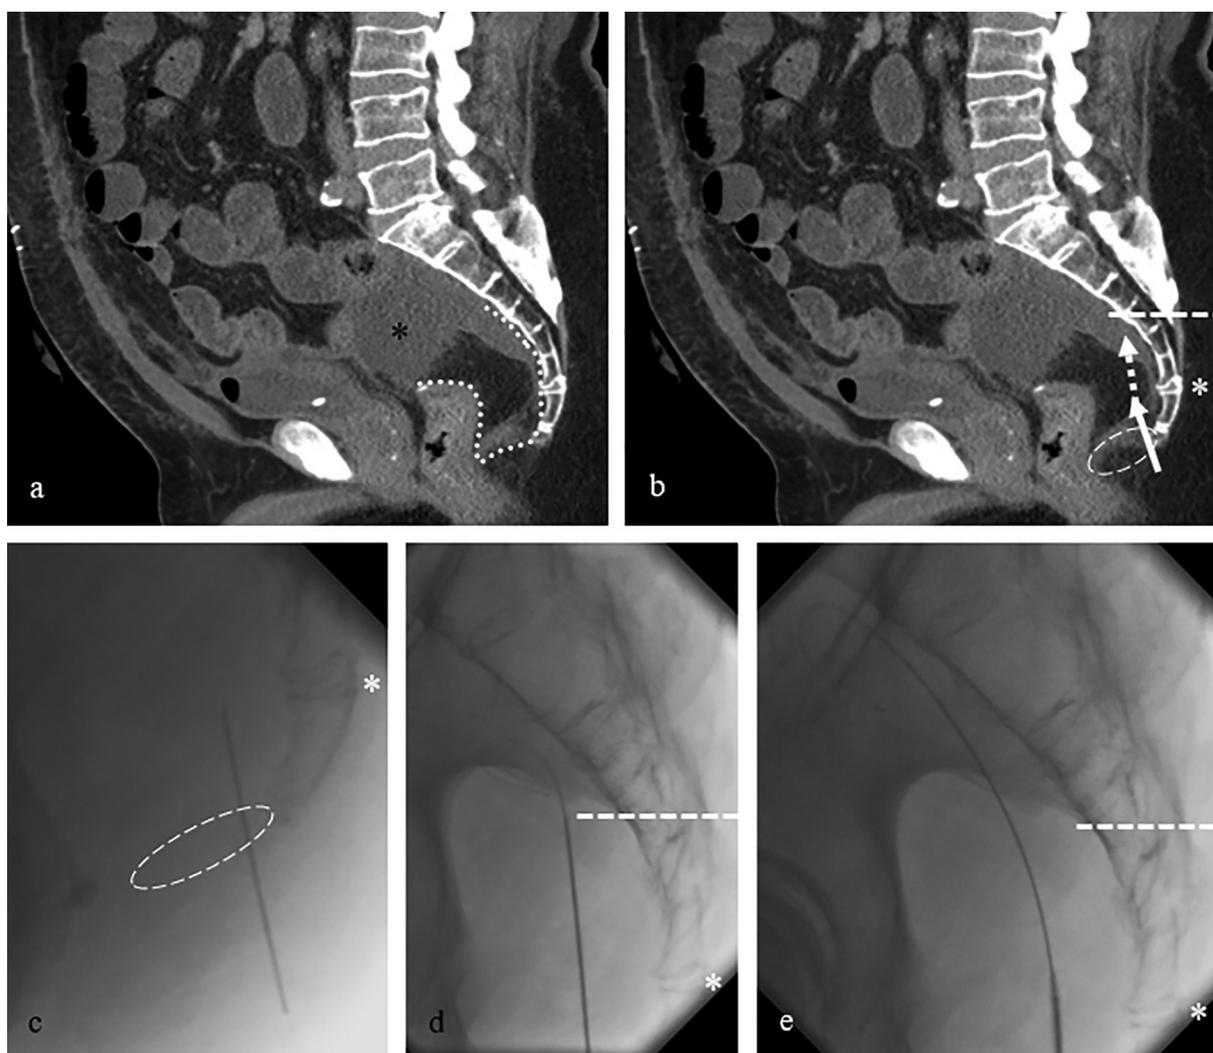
A 64-year-old man presenting with presacral abscess 10 days after low anterior resection: a–b: preprocedural CT images in the sagittal plane show a single simple presacral abscess with a volume of 250 cm^3 (black asterisk) extending caudally along the sacrum. The presacral space – the area between the rectal stump and the sacrum – (white dotted line) is quite voluminous and composed of fatty tissue. The posterior perineum, between the anus and the coccyx, is the puncture area (white striped ellipse). Determine landmarks (white asterisk and white striped line) for a safe puncture route. The trocar needle will be inserted towards the first landmark (white asterisk) as parallel as possible to the sacrum (white arrow) and will then be tilted further towards the sacrum (white striped arrow) to stay as far away as possible from the rectum, until reaching the second landmark (white striped line) at the level of the abscess; c: fluoroscopy image shows puncture of posterior perineum (white striped ellipse). The trocar needle is, as parallel to the sacrum as possible, inserted a few centimetres until reaching the level of the first osseous landmark (white asterisk); d: the trocar needle is tilted and inserted further towards the second osseous landmark (white striped line). After aspiration a guidewire is inserted; e: after needle withdrawal, the guidewire is placed further into the fluid collection.
